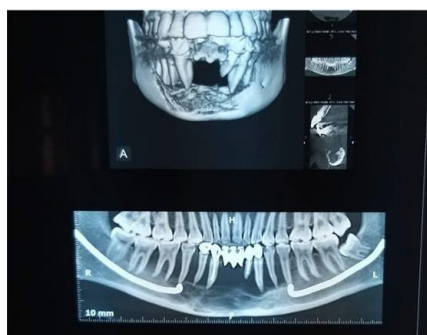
Orthopantomogram showing aggressive destruction of mandible in symphyseal and para symphyseal region from 33 to 43 was observed
